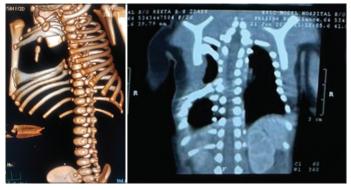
Contrast-enhanced computed tomography of thorax showed complete absence of the right 5<sup>th</sup> rib and part of 6<sup>th</sup> rib, with expansion and fusion of right 3<sup>rd</sup> and 4<sup>th</sup> rib, 7<sup>th</sup> and part of 6<sup>th</sup> rib, and crowding of 9, 8, 7, and 6<sup>th</sup> ribs with expansion of sternocostal joints while the rest of the ribs had no deformities with normal lung fields
